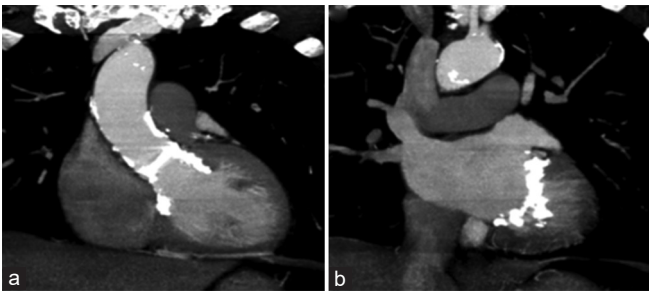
Cardiac computed tomography images from a 56-year-old man, 27 years' postmantle irradiation for Hodgkin's disease. Images demonstrate calcified aorto-mitral curtain and aorta (a), and mitral valve annulus (b)
